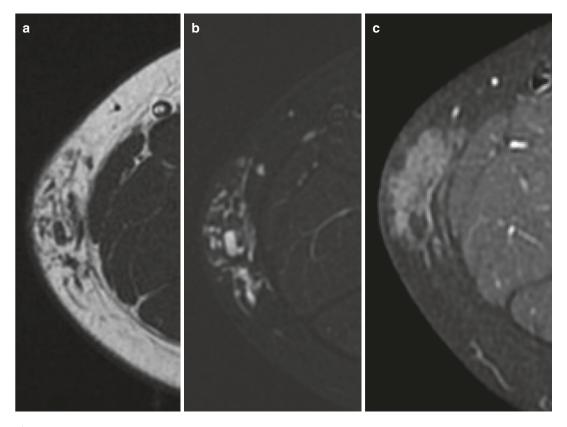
Ten-year-old boy with subcutaneaous venous malformation. (a) Axial T1-weighted MR image. (b) Axial T2-weighted MR image with fat suppression. (c) Axial T1-weighted MR image after Gadolinium contrast administration with fat suppression. (a) MR images show
